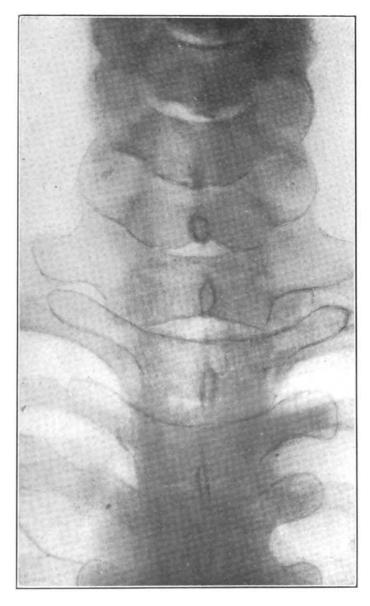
Radiograph of a lesion of the second dorsal vertebra. Note the approximation of the left transverse processes of the first and second dorsal vertebrae. Case of exophthalmic goitre following traumatic strain in this spinal area. Recovery.
